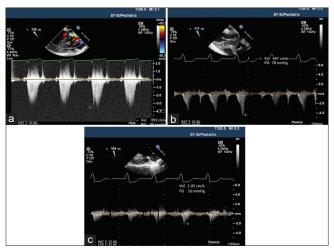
A continuous wave doppler trace across left ventricular outflow tract from transgastric long-axis view showing: (a) a peak gradient of 50 mmHg before surgical intervention, (b) a dagger-shaped left ventricular outflow tract continuous wave doppler trace post-subaortic membrane resection with peak systolic gradient of 78 mmHg; suggestive of dynamic nature of obstruction, (c) post-myectomy peak gradient across left ventricular outflow tract was 16 mmHg
